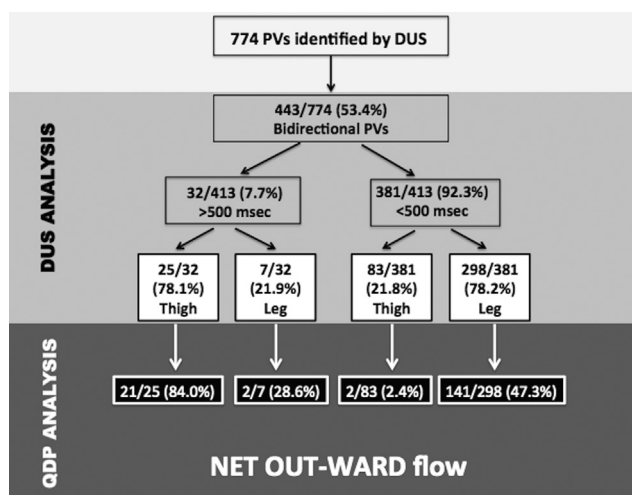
Perforating veins (PVs) assessed both by traditional duplex ultrasound (DUS) and quality Doppler profile (QDP) software.
